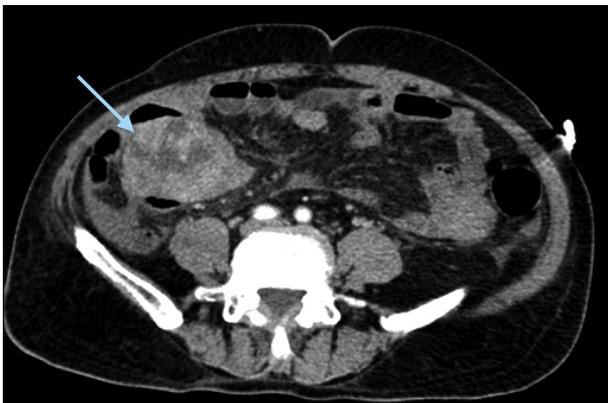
Computed tomography showing a 5 cm-sized enhancing mass (arrow) in the right flank adherent to small bowel.
